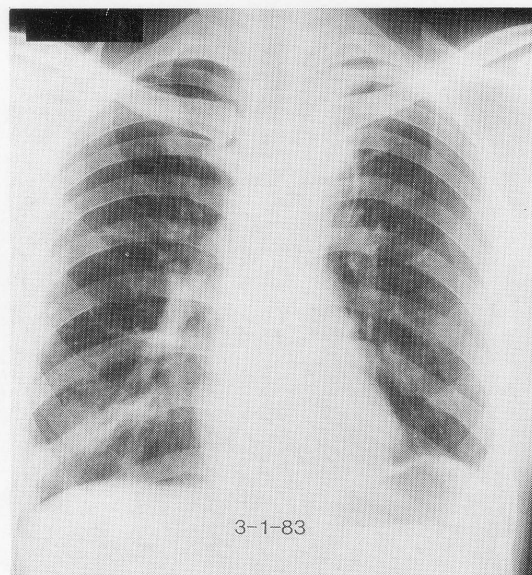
Postoperative chest radiograph (3-1-83).
